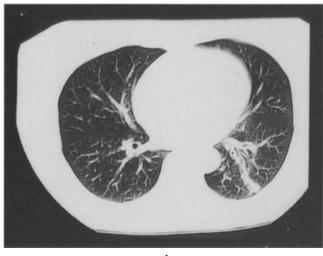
A 60 year old female smoking 20 cigarettes per day for 20 years. She became a nonsmoker for the 10 years prior to this radiograph. Chest radiograph (a) and CT (b) show heavy peribronchial and interlobar thickening.
